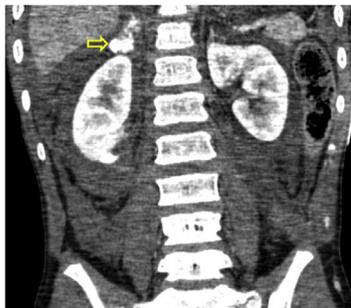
Coronal contrast enhanced CT scan of the abdomen showing extravasation of contrast in the right adrenal gland consistent with active bleeding (blush, arrow). Retroperitoneal and intraperitoneal hemorrhage were also identified.
